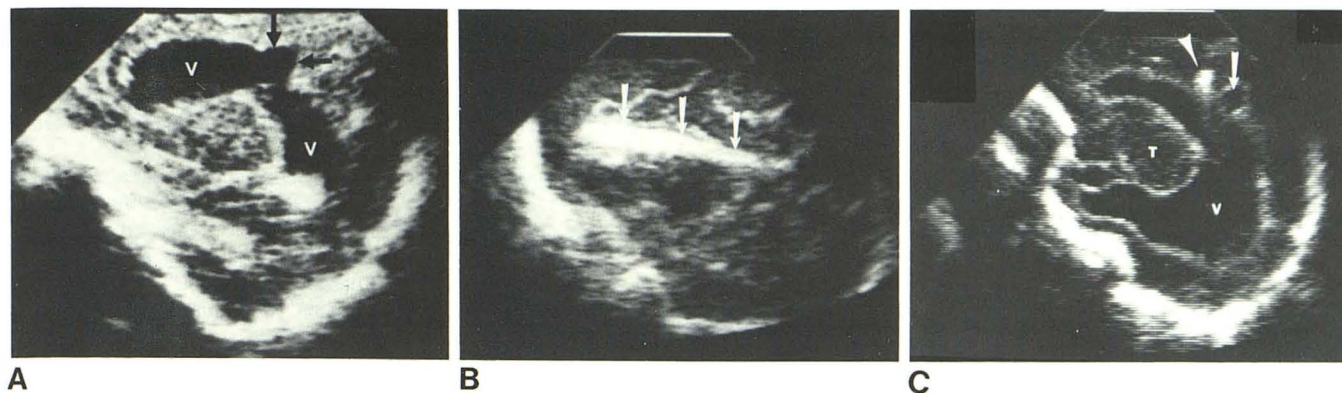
Response of cyst to shunting in 7-week-old infant, parasagittal sonograms. A, Small porencephalic cyst (arrows) and moderately dilated left ventricle (V). B, After ventriculoperitoneal shunt. Ventricles and porencephalic
